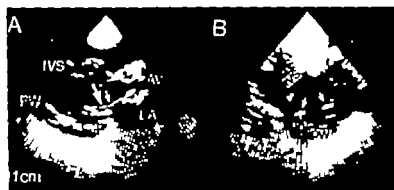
Normal cross-sectional echocardiogram. Long axis (A) and short axis (B) views. Each frame was recorded in late systole. In A coaptation of the anterior and posterior mitral leaflets takes place at their free edges (*large arrow*) and slight arching toward each other is noted (*small arrow*). In B the papillary muscles are visualized in short axis (*two white arrows*). The posteromedial papillary muscle is located on the left and the anterolateral papillary muscle on the right. The echo density of the papillary muscles is similar to the adjacent myocardium. IVS = interventricular septum; PW = posterior left ventricular wall; AV = aortic valve; LA = left atrium. The same abbreviations are used in Figs. 2 through 8.
